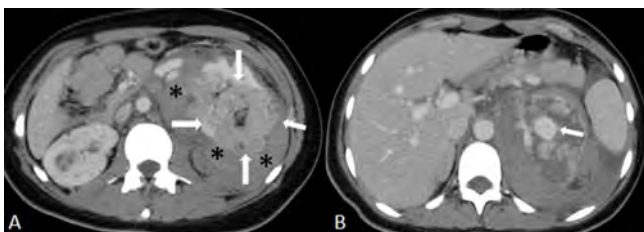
In contrast enhanced multidetector computed tomography (MDCT) showed heterogeneous lesion of maximum diameter of 74x98 mm of the left kidney (arrows) expanding into the perirenal space associated with a perinephric hematoma (asterisks) (A) and a few aneurysms presented within the tumor (arrow) (B)
